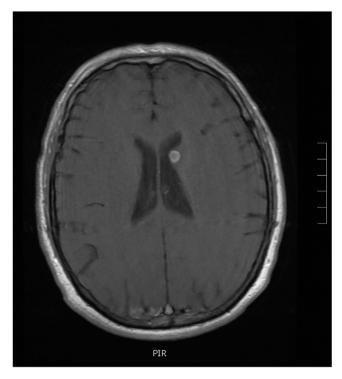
MRI of the head with gadolinium shows a T2 hypointense lesion involving the left head of the caudate nucleus with perifocal edema suspicious for a fungal abscess.
